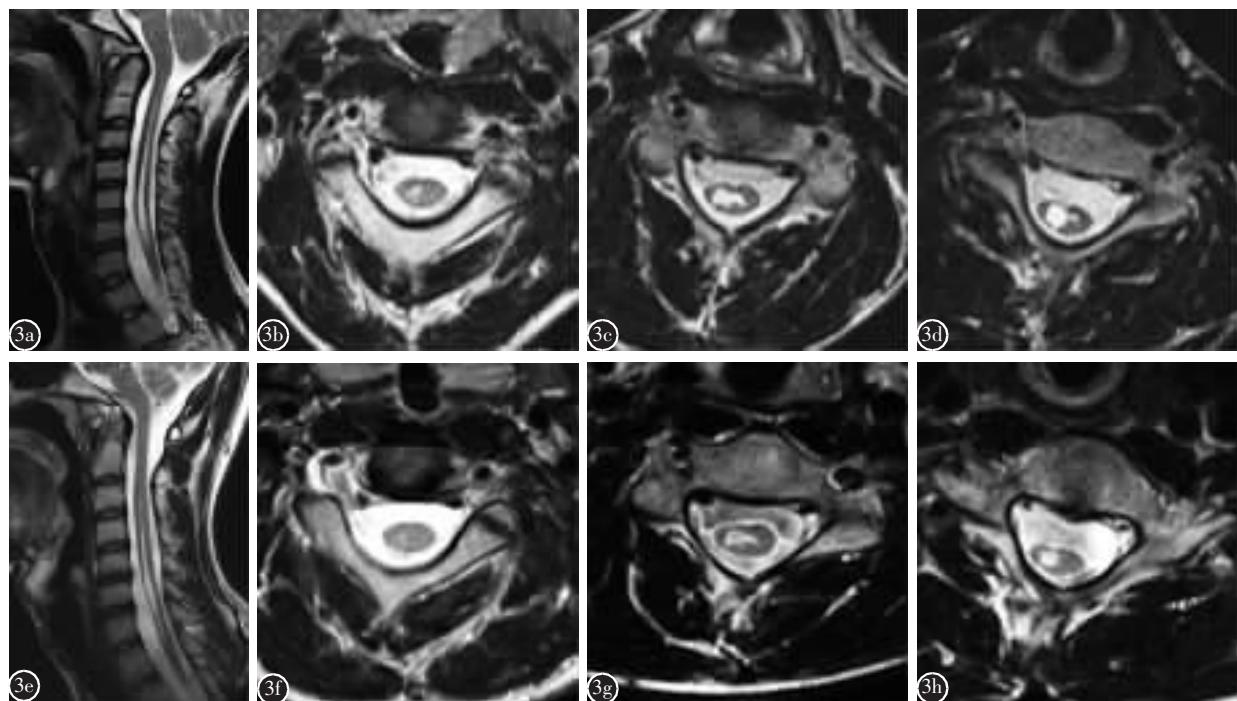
病例 12 一期脊柱矫形术后脊髓空洞改善(MRI T2 加权像) a 术前矢状位成像显示颈段脊髓有空洞 b-d 分别为术前 C2、C4、C6 下终板水平的横切面成像, 平均颈脊髓空洞张力指数(CSTR)为 0.46 e 在术后 8 年随访时, 矢状位成像显示颈段脊髓空洞长度缩短 f-h 分别为术后 8 年随访时 C2、C4、C6 下终板水平的横切面成像, 显示脊髓空洞缩小, 平均 CSTR 降至 0.31, 脊髓空洞改善率为 32.6%
